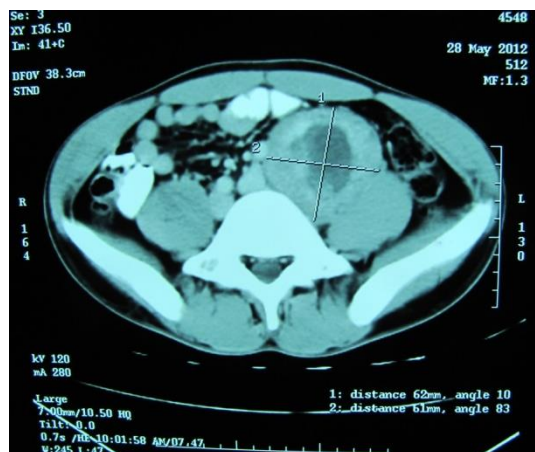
CT scan showing schwannoma.
